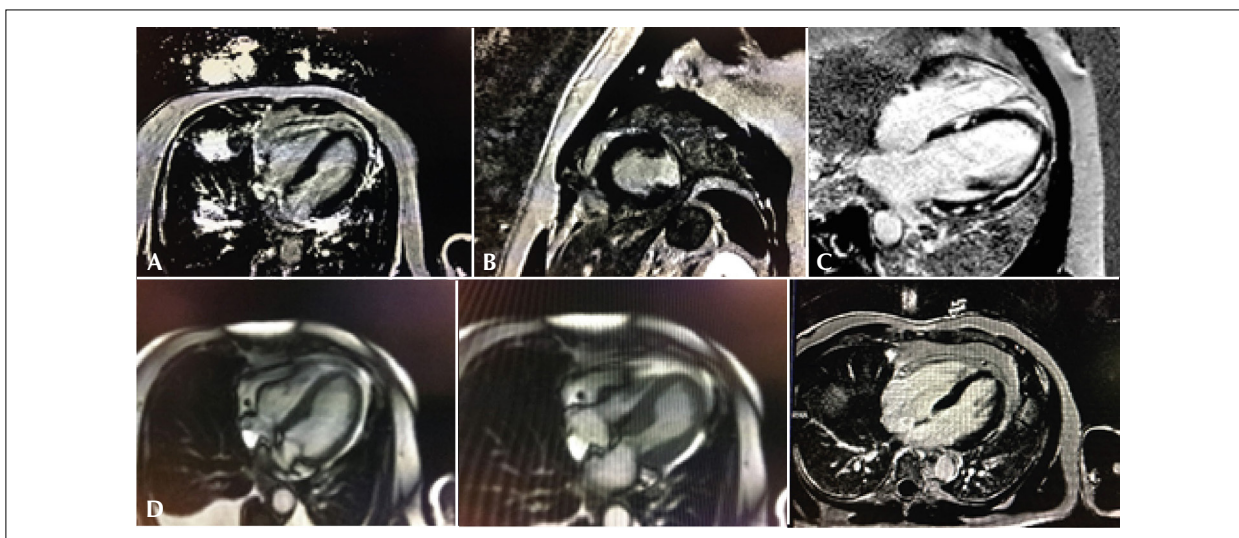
Cardiac magnetic resonance images of patients with normal study findings using the delayed enhancement technique (1A); transmural infarction in the lateral wall (1B), myocarditis pattern (1C), and Takotsubo cardiomyopathy showing medium-apical contractile deficit and no changes using the delayed enhancement technique (1D).
